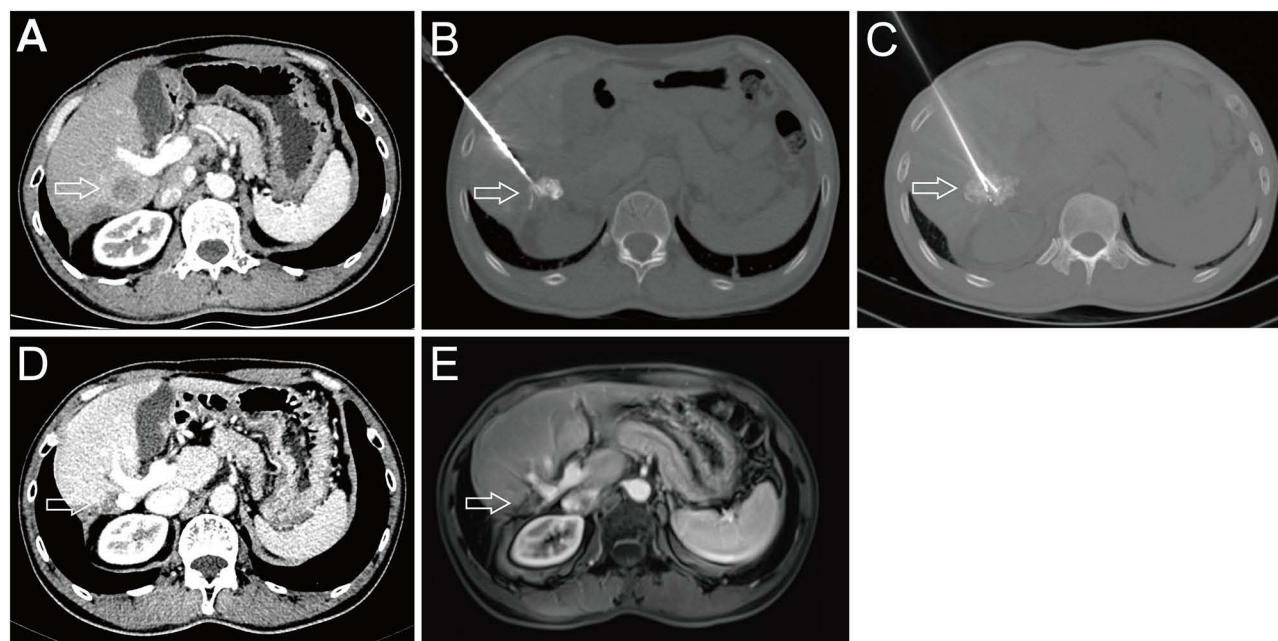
A 58-year-old male patient with an unresectable HCC in high-risk locations received the TACE-RFA- ^{125}I treatment. (A) A contrast-enhanced CT scan showed a 3 cm HCC (white arrow) near the right branch of the portal vein and the right kidney. (B) The RFA treatment for HCC (white arrow) was performed after the TACE. (C) The ^{125}I seed implantation for HCC (white arrow) was performed after the RFA treatment. (D-E) The follow-up at seven years after TACE-RFA- ^{125}I treatment with contrast-enhanced CT and MRI showed a significant shrinkage of tumor size (white arrow), and there was no enhancement of the tumor. Meanwhile, the AFP value decreased from the initial 2800 $\mu\text{g/L}$ to 2.7 $\mu\text{g/L}$ in the last follow-up. The treatment effect of HCC in this patient was a complete response according to the modified Response Evaluation Criteria in Solid Tumors.
